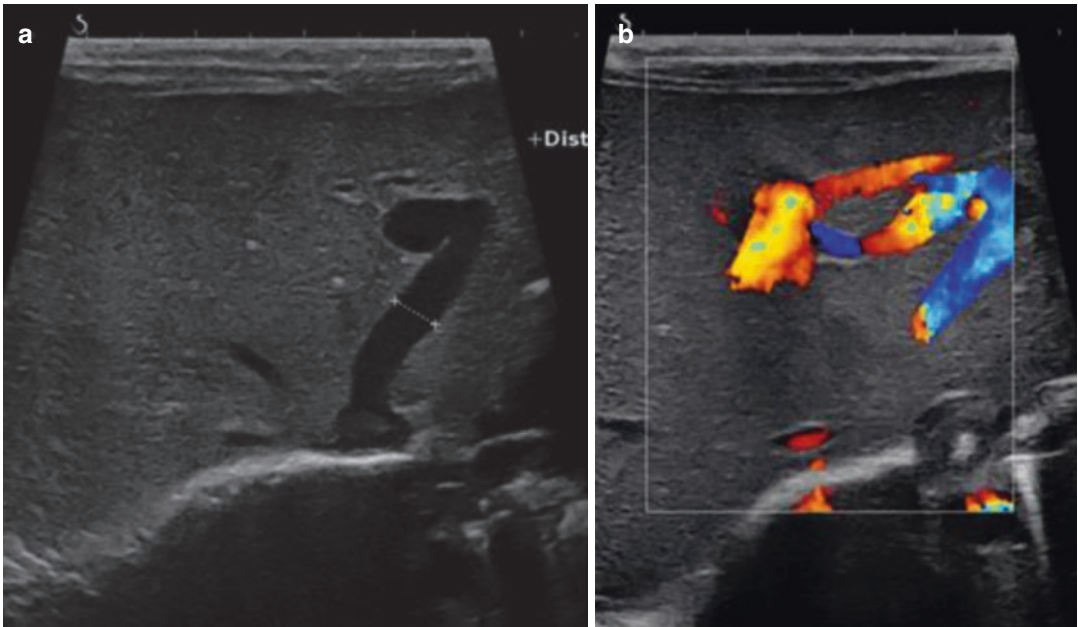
Porto-hepatic fistula between the left portal branch and the left hepatic vein on (a) B-mode, (b) Color Doppler
